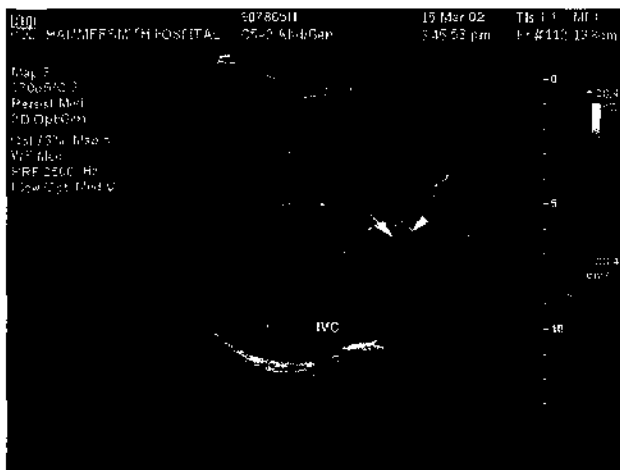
Normal liver—porta hepatis. In a longitudinal section through the porta hepatis, the uniform texture of the liver parenchyma can be seen. In the color Doppler scan, the portal vein is depicted in red (see Plate 2), indicating flow toward the transducer. The hepatic artery (arrow), also in red, can be discerned anterior to it, and the dark circle (arrowhead) is the right hepatic duct seen in cross-section. The position of the duct represents a normal variant: usually it lies between the vein and the artery. IVC, Inferior vena cava.
